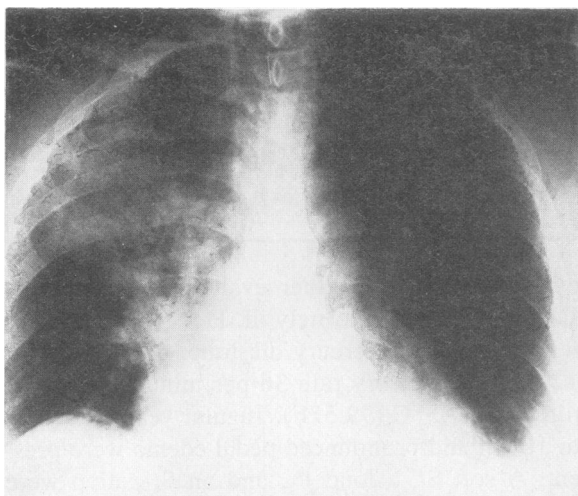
(Case 1) Frontal portable roentgenogram of the chest shows dense, right upper lobe consolidation. The remainder of the lung fields is essentially clear.
